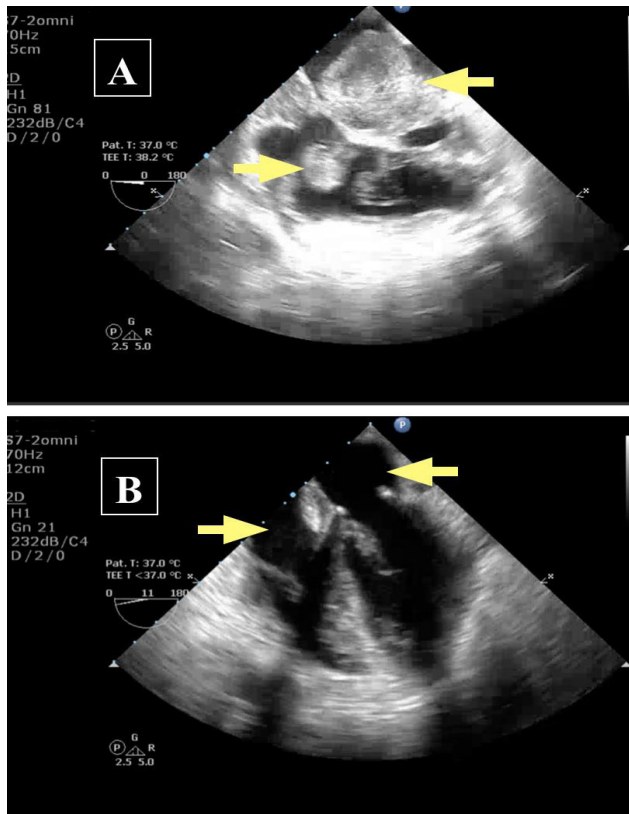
Intra-operative transesophageal echocardiogram (A) Mid-esophageal view showing the biatrial mass prior to surgical resection (yellow arrow) (B) Mid-esophageal view showing complete surgical resection of the mass (Yellow arrow).
